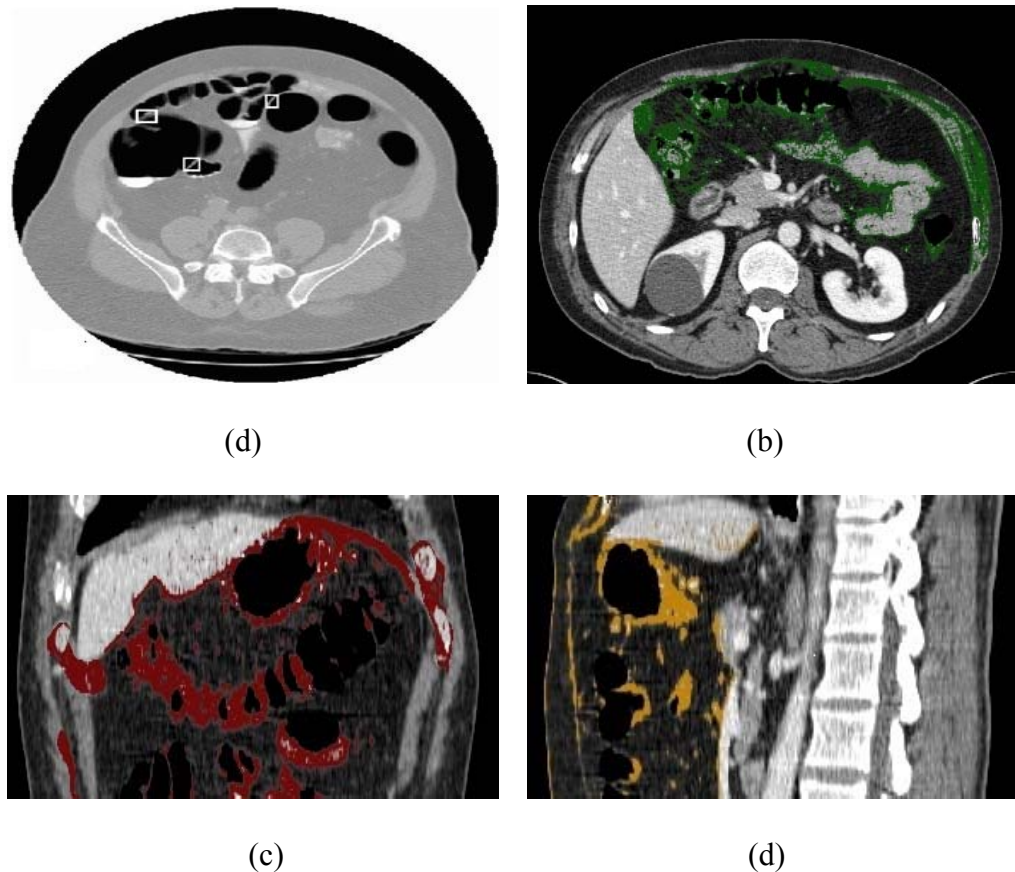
CT image examples for visualization of intestines (a) image from (Bakker et al. 1999) shows a typical 2-D CT slice. The rectangular frames show thin walls with air on both sides. Moreover, colon can be buried in the residue fluid and some parts might be collapsed in sigmoid colon, (b) Axial image (original slicing axis), the outer walls of intestines with stomach both of which are filled with air. Selecting more units results in overlapping with spleen, (c) Reconstructed coronal images where the overlapping with has been solved but intestines and stomach can not be differentiated, (d) Reconstructed sagittal images where the same affect still exists.
